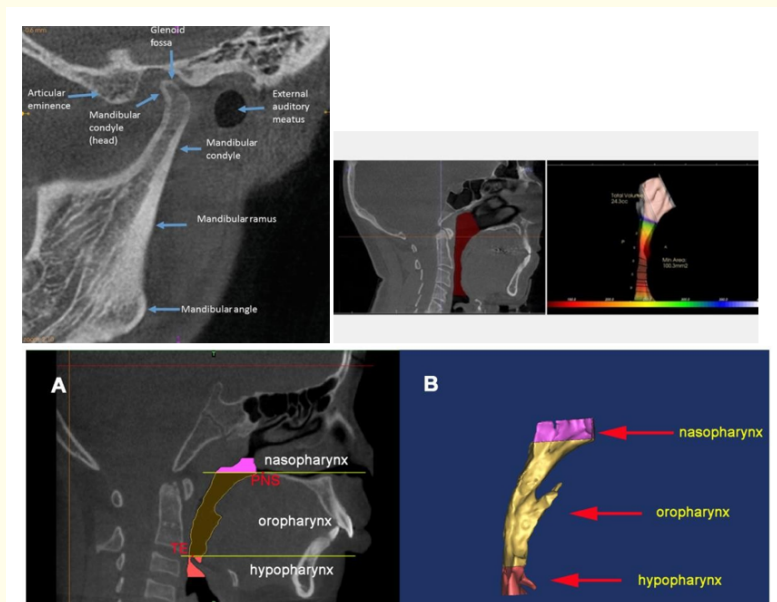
Radiological investigation: CBCT scan - TMJ and airway evaluation.
